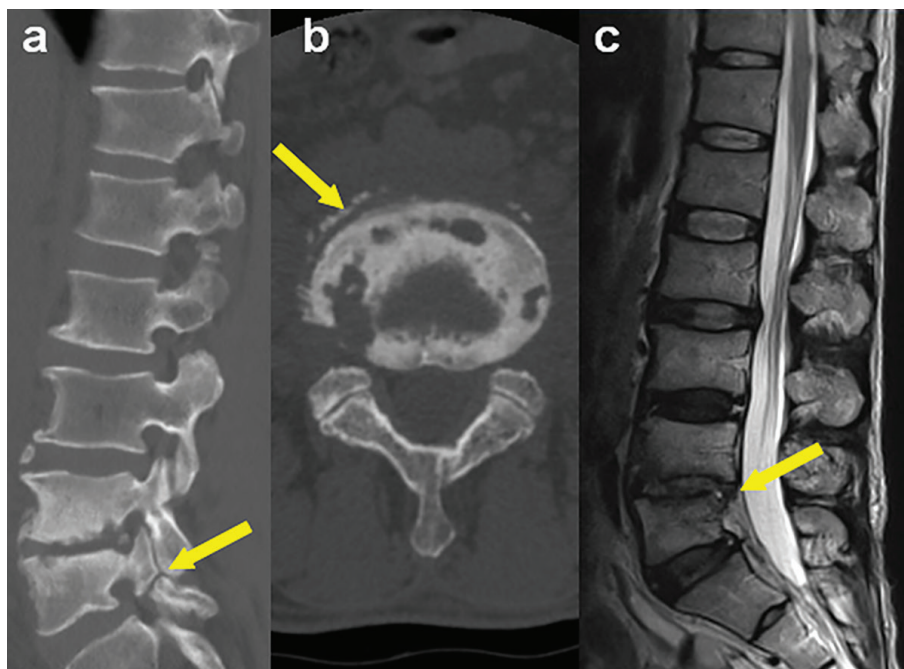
FIGURE A - CT revealed intervertebral destruction and narrowing at L4-5, and I° lumbar spondylolisthesis with posterior displacement (arrow in FIGURE A-a). There was marginal damage of the centrum as well as hyperostosis osteosclerosis. The margin of the centrum showed lace-like changes (arrow in FIGURE A-b). MRI revealed L4-5 intervertebral disc tissues, and the L4-5 vertebral bodies were hypointense, heterogeneous, and heterogeneous on T1WI, T2WI and STIR images, respectively (arrow in FIGURE A-c). CT: computed tomography; MRI: magnetic resonance imaging; T1WI: T1 weighted imaging; T2WI: T2 weighted imaging; STIR: Short time inversion recovery.
